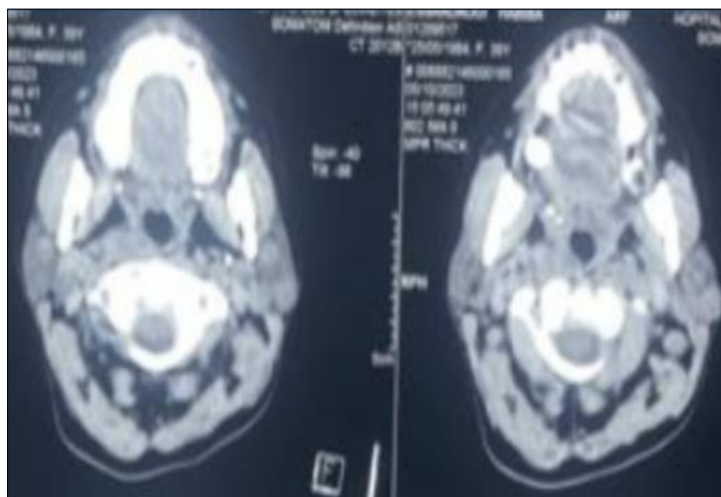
Axial CT scan of the cervical region after contrast injection showing well-defined, rounded, hypodense cervical lymphadenopathies
